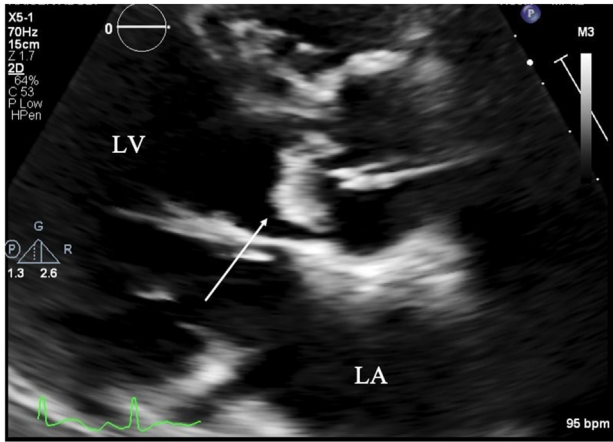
Two-dimensional TTE, parasternal long-axis zoom view, diastolic phase, demonstrates a large, echogenic mass in the LV outflow tract consistent with an aortic valve vegetation. LA, Left atrium.
